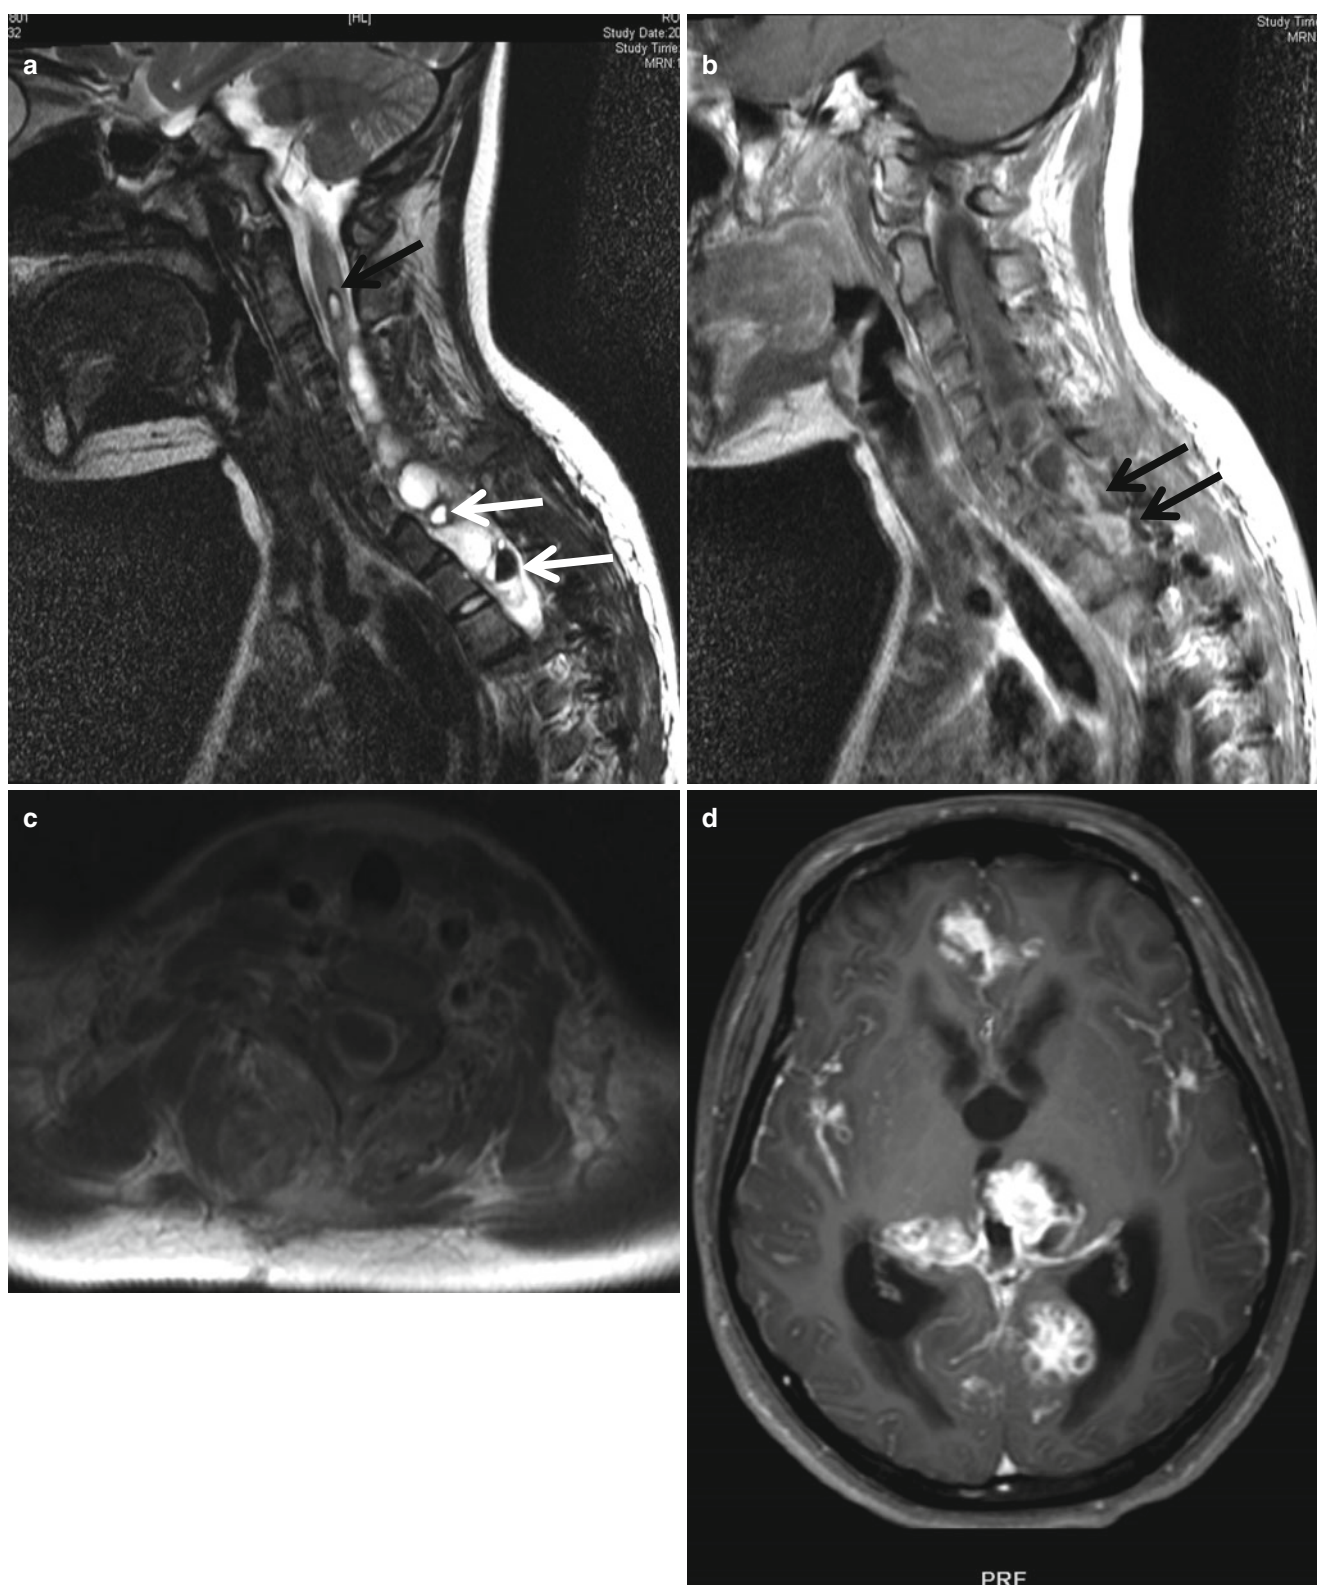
Anaplastic ependymoma with CSF dissemination. (a) T2-weighted sagittal image demonstrates multicystic mass involving long segmental cervicothoracic cord. Lower spinal cavity is not visualized due to scoliotic curvature of the spinal column. Dark uppermost cystic wall (arrow) as well as multiple fluid levels within the cysts
